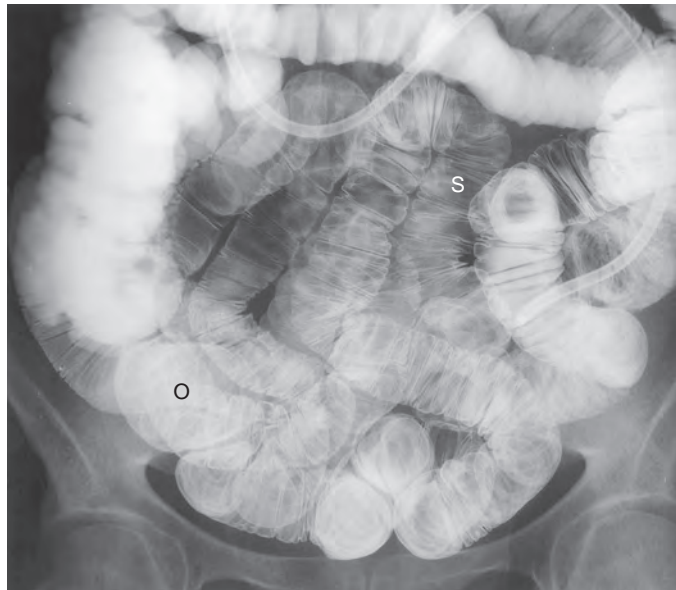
Methylcellulose-contrast enteroclysis. Overhead radiograph obtained at the end of the enteroclysis examination shows exquisite anatomic detail in nonoverlapping loops (S). Anatomic detail may be difficult to visualize, however, when loops overlap (O), even though the methylcellulose allows partial visualization of these overlapping loops, termed a *transradiant effect*.
